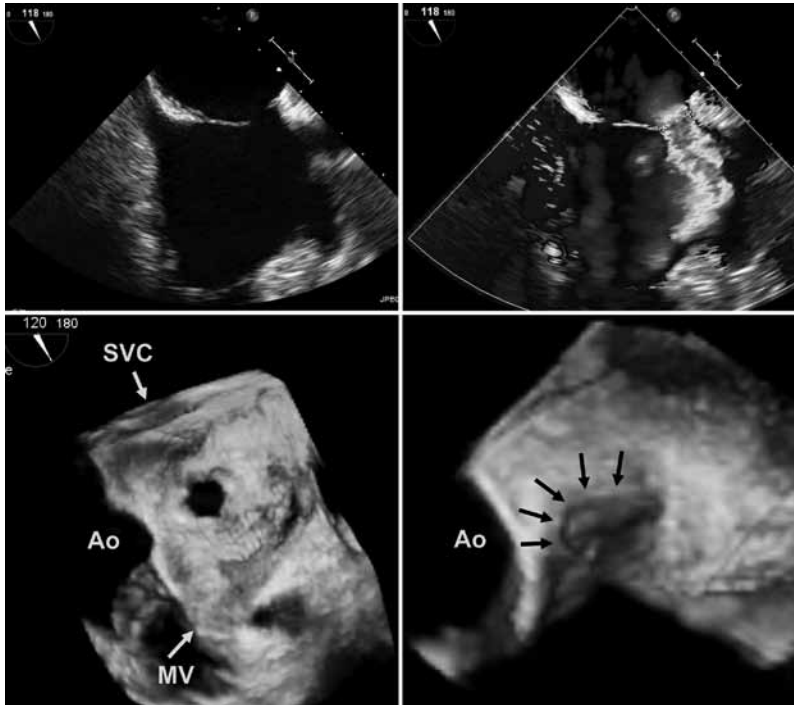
Comparison of transesophageal 2D versus live 3D representation of an ostium secundum ASD with a small rim towards the aortic wall (anterior-superior). The 3D en face view from the left atrium towards the interatrial septum (IAS) shows the exact shape and size of the defect and its anterior-superior location in the IAS (bottom left). The zoomed 3D representation allows exact detection of the extent and width of the anterior-superior rim and its relation to the aortic wall (bottom right). SVC superior vena cava, Ao aortic root, MV mitral valve.
